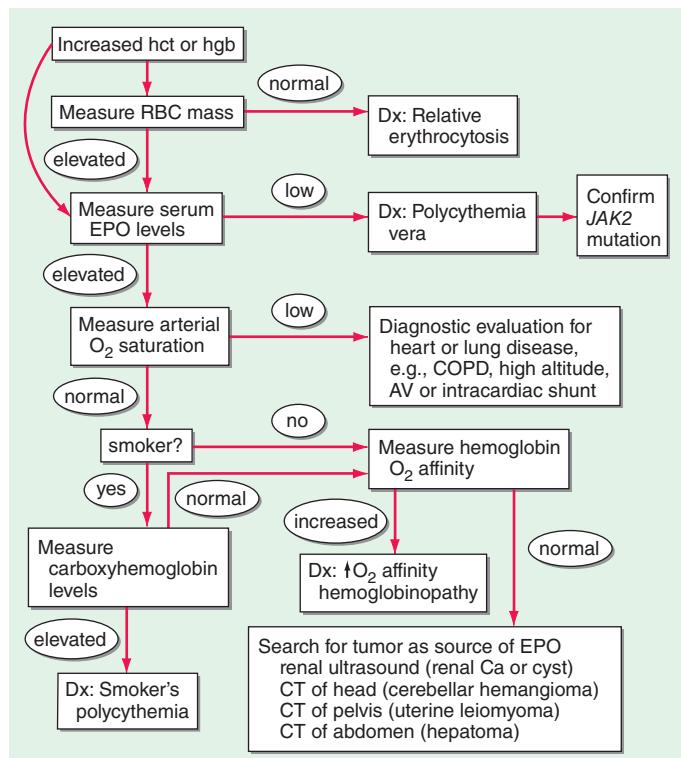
An approach to the differential diagnosis of patients with an elevated hemoglobin (possible polycythemia). AV, atrioventricular; Ca, calcium; COPD, chronic obstructive pulmonary disease; CT, computed tomography; EPO, erythropoietin; hct, hematocrit; hgb, hemoglobin; IVP, intravenous pyelogram; RBC, red blood cell.
